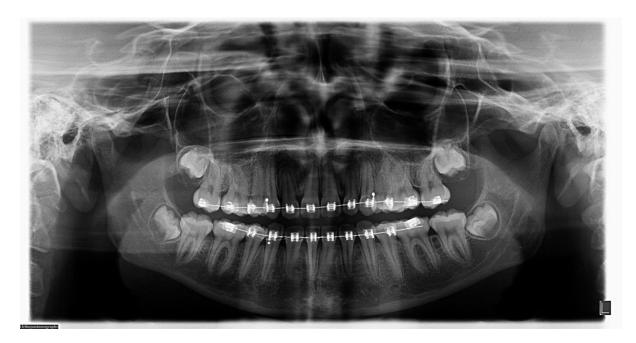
Digital panoramic radiograph of a 17.62 year old white South African female. According to the classification system the left maxillary third molar can be classified as a stage E and the left mandibular third molar as stage D.
